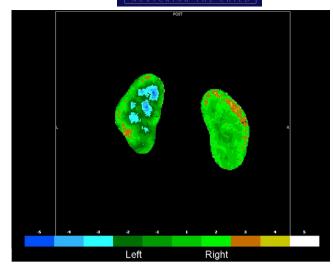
Dimercaptosuccinic acid scintigraphy during the acute phase of the disease showed decreased uptake of the isotope in the left kidney, with a reduction in relative function of 43%, compared to 57% in the right kidney. This confirmed acute pyelonephritis. The colours correspond to the intensity of perfusion, according to the scale on the bottom of the figure
